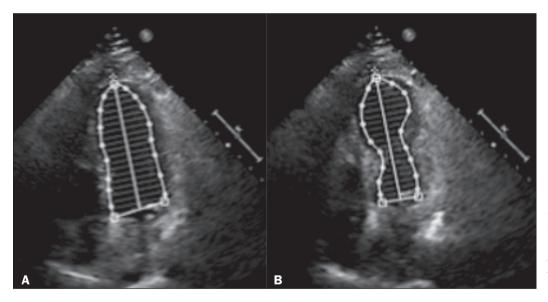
Four-chamber echocardiogram images, in diastole (A) and systole (B), showing hypokinesia in the apical region of the LV, together with hyperkinesia in the basal segments, resulting in the characteristic takotsubo morphology
